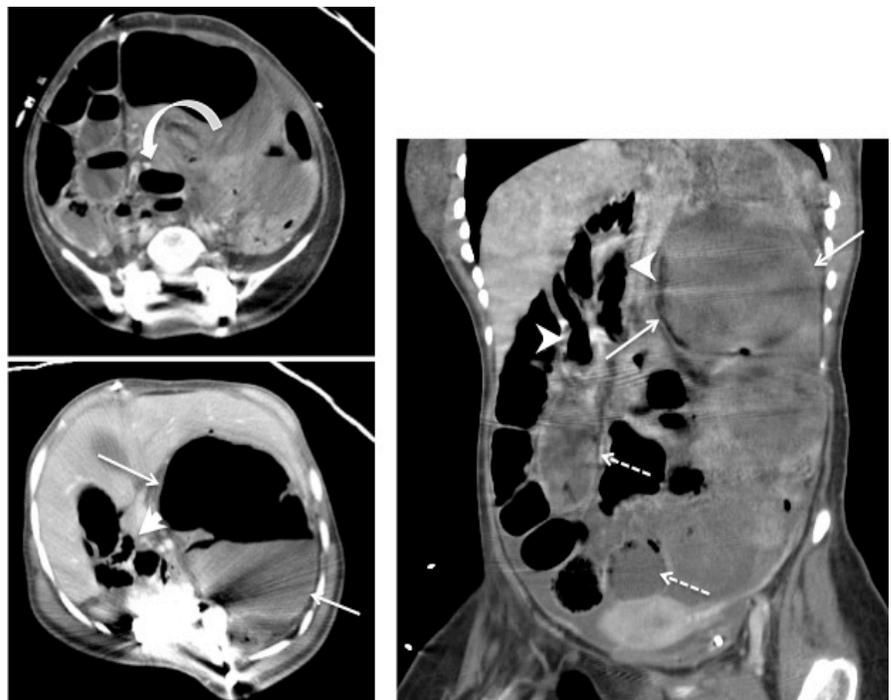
Axial (a and b) and coronal (c) CT images of the abdomen demonstrate a markedly dilated cecum located in the left upper quadrant (arrows) that is twisted with a whirl sign (curved arrow) in the mid abdomen. Note the predominance of bowel loops in the right abdomen (arrowheads) with distal small bowel dilation (dashed arrows).
